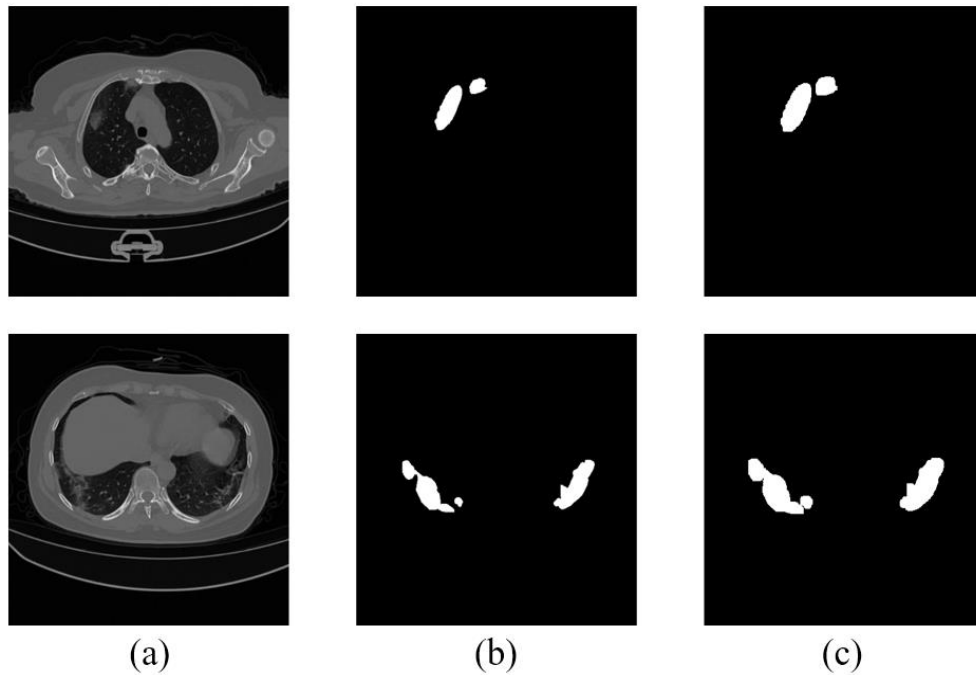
Segmentation Outcomes on COVID-19 CT Images. (a) Original Image. (b) CAED [105]. (c) Proposed OU-Net with MGWO.
